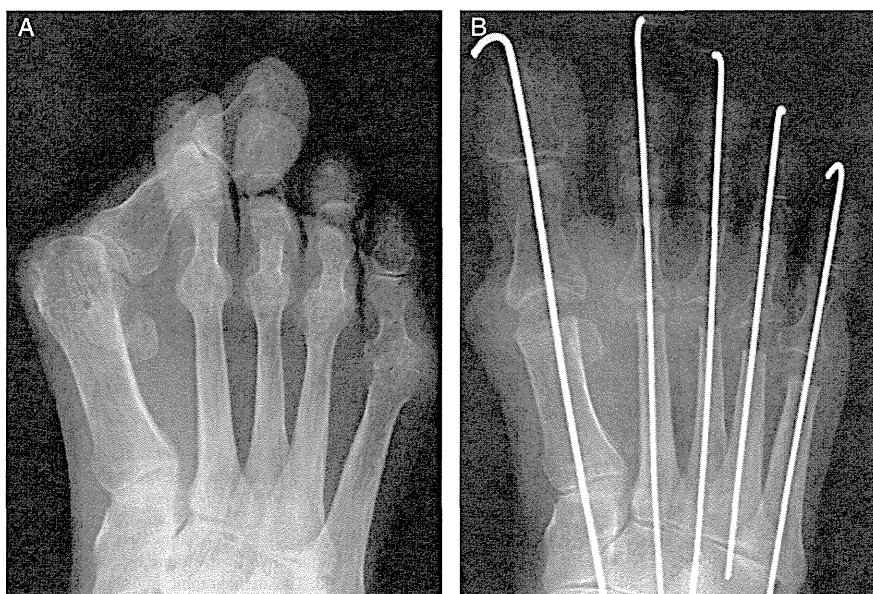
(A) Standing preoperative anteroposterior radiograph. (B) Standing anteroposterior radiograph of the same foot immediately postoperatively with resection of all 5 metatarsal heads.
